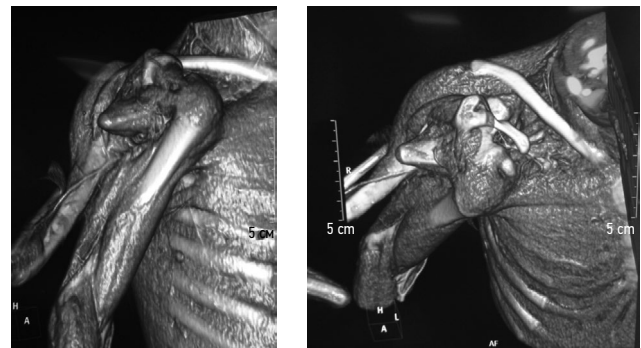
Data from multislice computed tomography with vascular opacification
